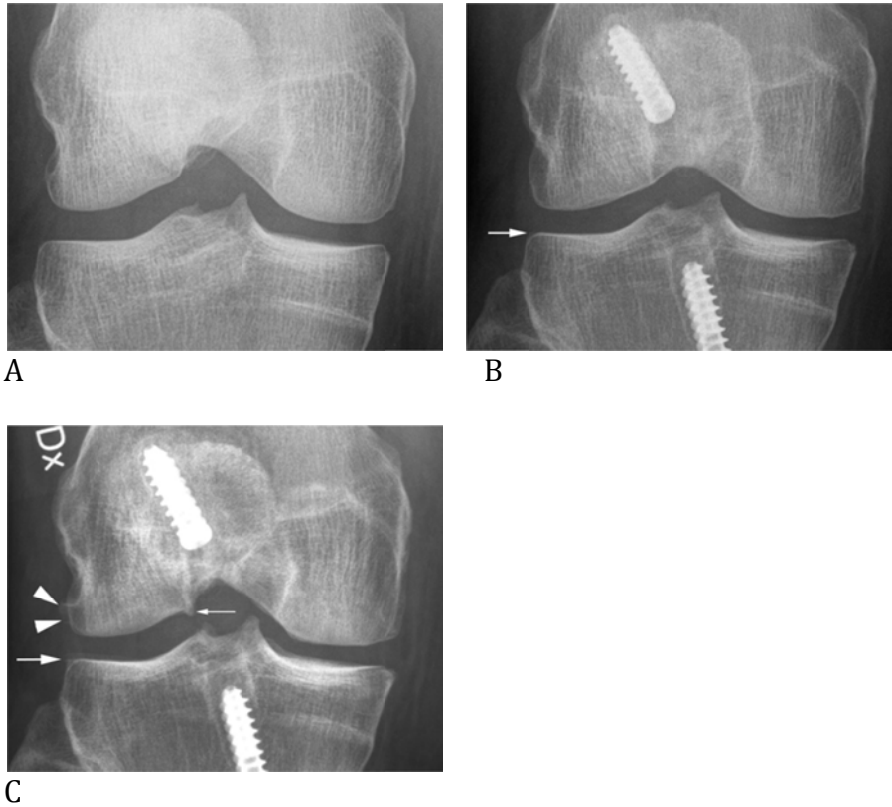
Radiographic osteoarthritis development over 5 years. A. AP radiograph at baseline obtained directly after trauma shows no signs of radiographic osteoarthritis. Normal medial and lateral joint space width and absence of osteophytes are observed. B. 2 year follow-up image shows metallic screws in the femur and tibia after ACL reconstruction. Normal joint space width is observed. There is a tiny equivocal marginal osteophyte at the lateral tibial plateau. C. At 5 years follow-up definite osteophytes are observed at the lateral femoral condyle (arrowheads) and tibial plateau (large arrow) representing radiographic osteoarthritis grade 2 according to the Kellgren-Lawrence classification scheme. In addition there is a prominent notch osteophyte at the lateral femoral condyle potentially causing ligament impingement (small arrow).
